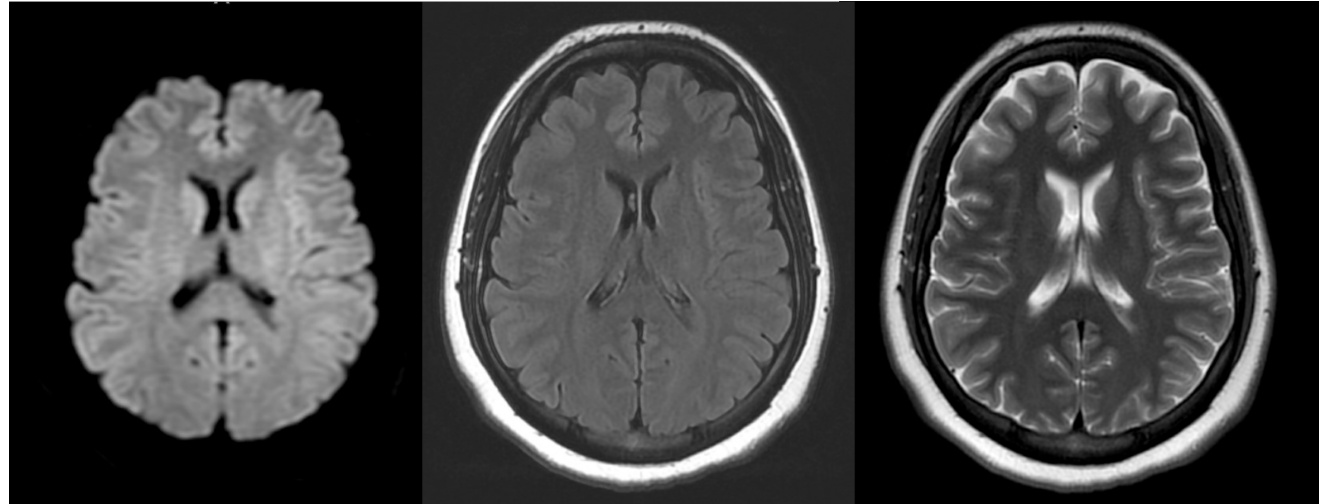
Patient's repeat axial MRI brain images one month later (sequences from left to right are DWI, T2WI, T2-FLAIR) demonstrating resolution of cytotoxic lesions of the corpus callosum.
